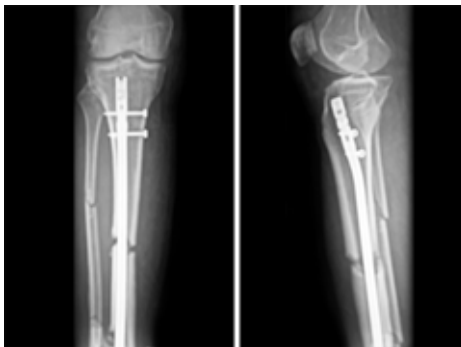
X-ray knee with leg AP and lateral views showing CRIF of tibial fracture with intramedullary nailing.
